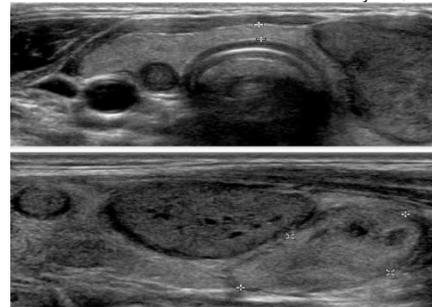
shows thyroid nodules that appear purely cystic, or filled with fluid. 2b: Nodules that do not have smooth borders or have little bright white spots (micro-calcifications) on the ultrasound would make suspicious that there is a thyroid cancer present.<sup>39</sup>
